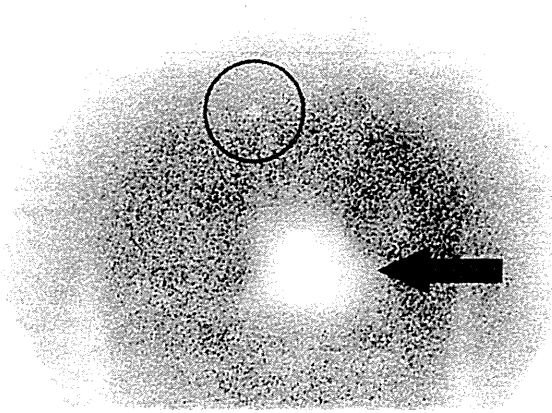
Lymphoscintigraphy for sentinel lymph node mapping. The black arrow indicates uptake of radioisotope in the primary tumor. The black circle indicates a hot spot
